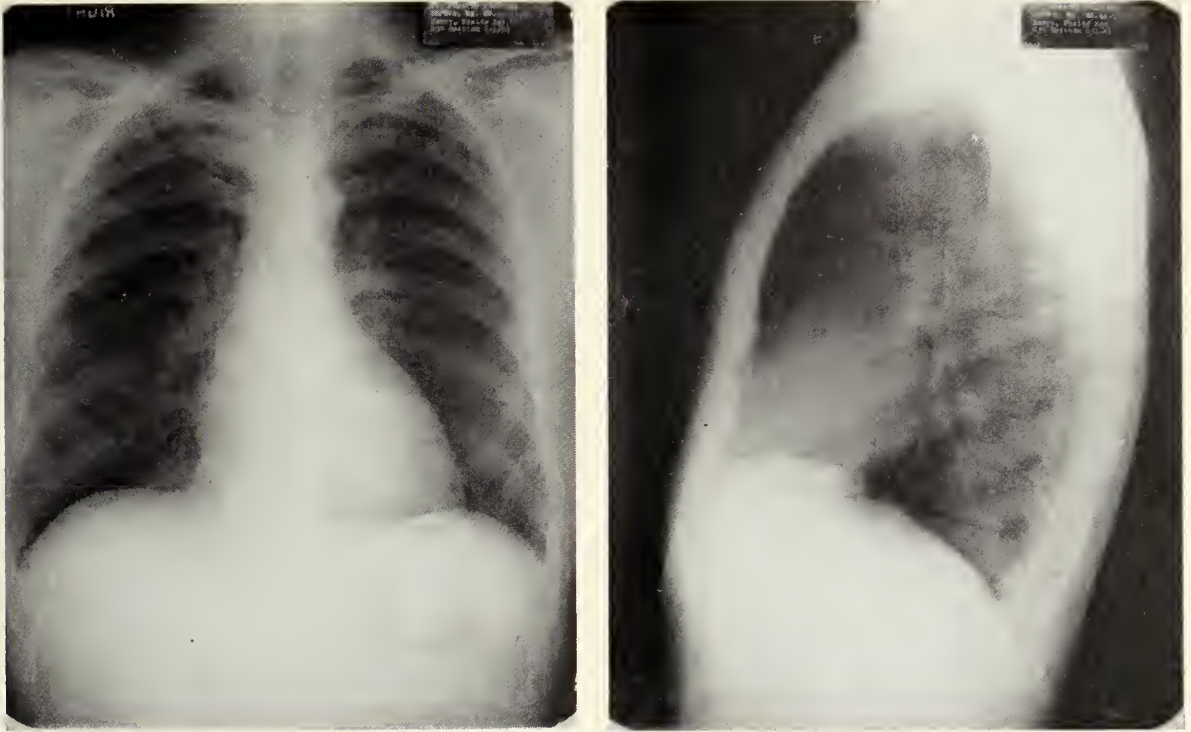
Chest x-rays showing striking reduction in heart size and disappearance of pleural effusion.
